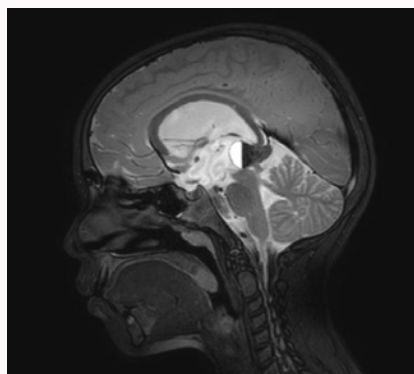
Sagittal T2-weighted image showing a pineal lesion with solid and cystic component containing layering blood products.
